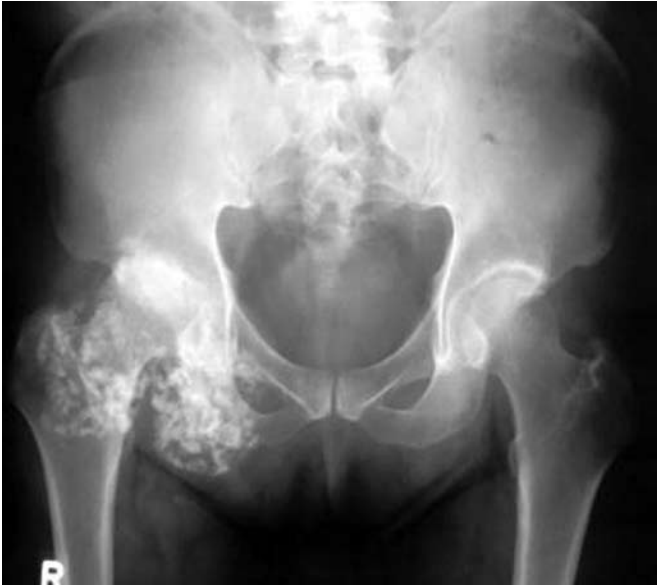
Anteroposterior pelvic radiograph of a 55-year-old man with synovial osteochondromatosis shows numerous densely-ossified loose bodies confined within and distending the capsular margins of the right hip joint. There are associated degenerative changes and marked joint space narrowing. The left hip is normal.
